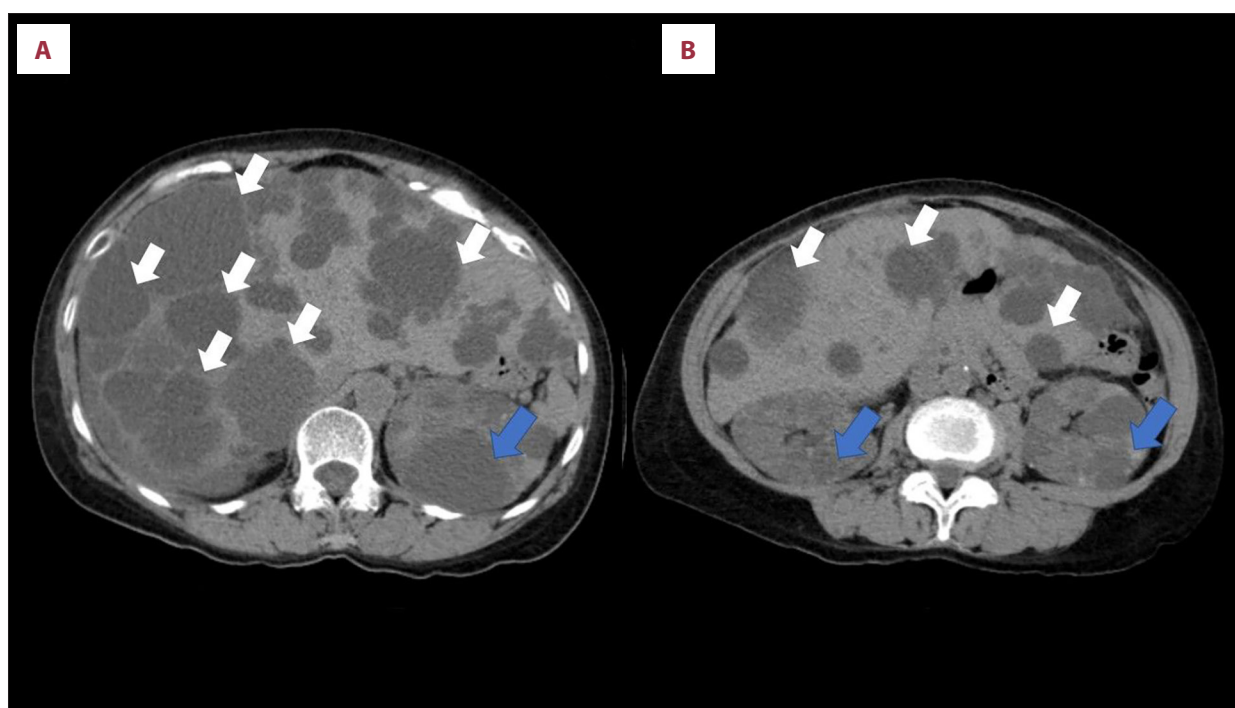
Contrast-enhanced computed tomography of the abdomen. Axial contrast-enhanced computed tomography images (A, B) demonstrate numerous hypodense ovoid lesions of varying sizes throughout the liver (white arrows) and both kidneys (blue arrows), consistent with hepatic and renal cysts.
